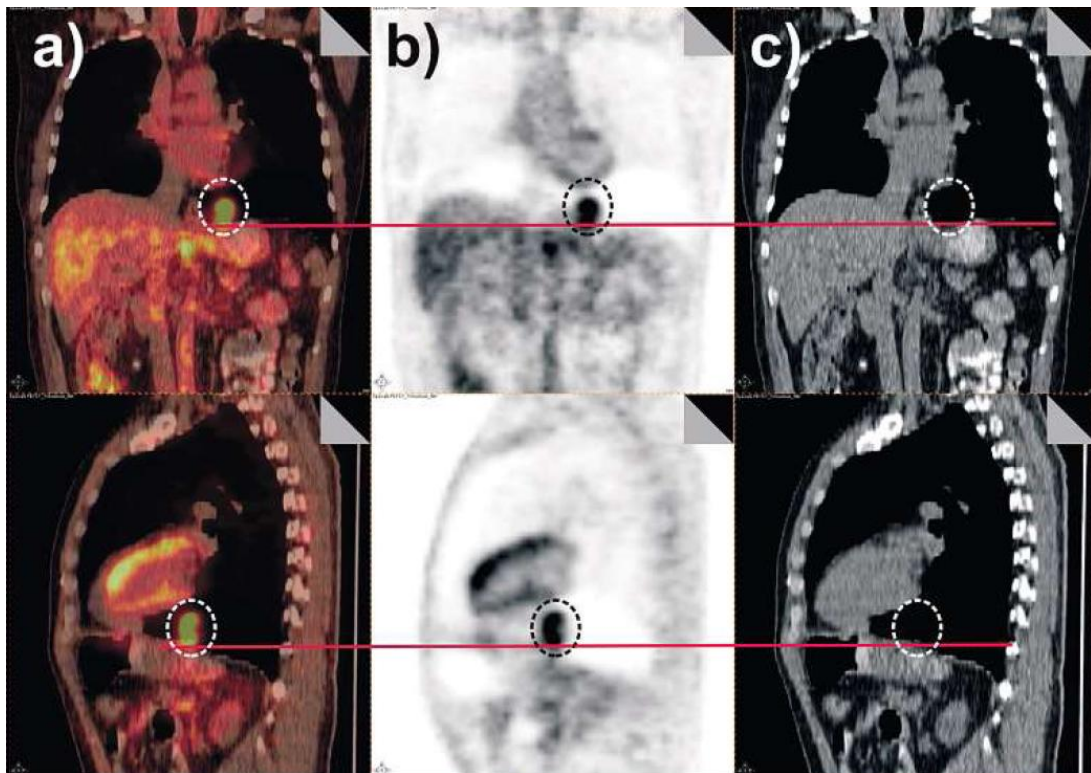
Patient with an adenocarcinoma of the oesophagogastric junction showing a notable PET-CT misregistration. Fused PET/CT (a), PET (b) and CT (c) images, showing that the focal uptake in the tumor corresponds to lung tissue in the CT. Reproduced from [48] with permission from Schattauer.
